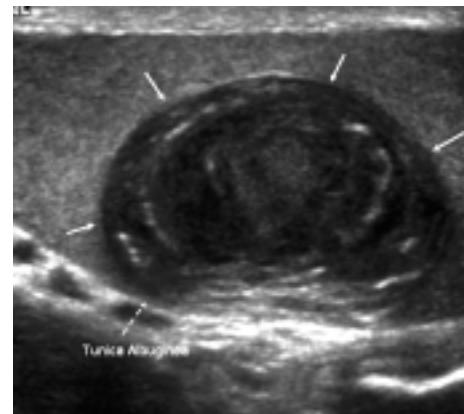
Ultrasound of right testis (longitudinal) demonstrating a 3 cm well-margined mass with concentric rings of hypoechogenicity and hyperechogenicity as well as a centre that is slightly echogenic.
